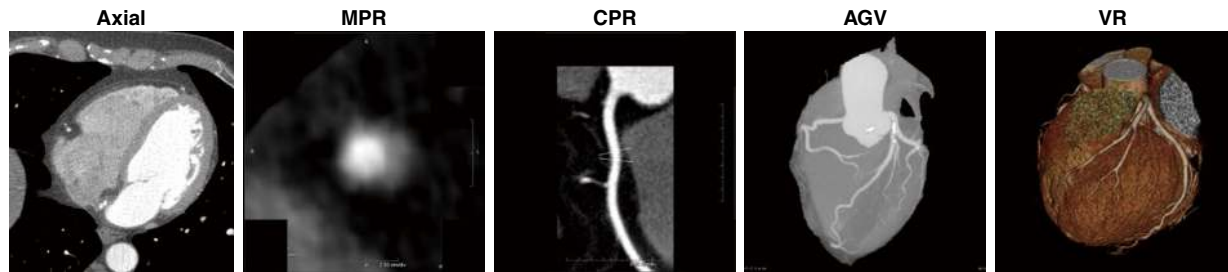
Various image reconstruction formats in cardiac CT. AGV, angiographic view; Axial, axial image; CPR, curved planar reformat; MPR, multiplanar reformat; VR: volume rendering.
